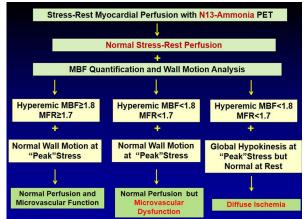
Algorithm for the integration of ¹³N-ammonia PET/ CT perfusion images, MBF, and wall motion analysis for differentiation between microvascular dysfunction and diffuse ischemia. Combining hyperemic MBFs and wall motion analysis at "peak" stress affords the differentiation between predominant microvascular dysfunction and diffuse myocardial ischemia owing to significant left main and/or three-vessel CAD. For example, balanced reductions in hyperemic MBFs and normal wall motion of the left ventricle at peak stress argue for the presence of predominantly microvascular disease but not diffuse ischemia. Conversely, diffuse reductions in hyperemic MBFs associated with transient ischemic cavity dilation (TID) of the left ventricle during vasomotor stress on gated PET images is widely specific for the presence of diffuse ischemia.1,51,94
